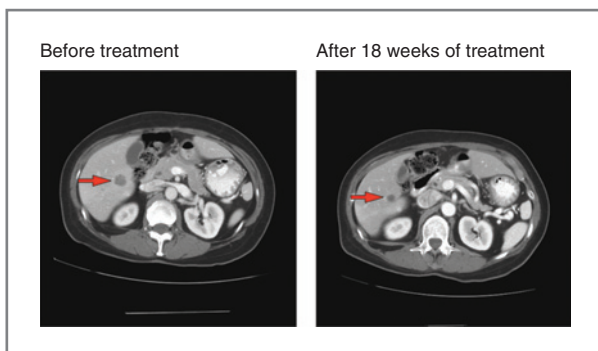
Computed tomography scans of responding patients. Patient with endometrial cancer demonstrating partial response in liver metastases. Arrows, locations of metastases.
